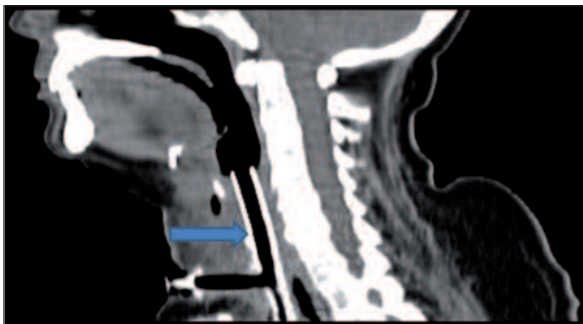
Computed tomography image of the patient one month after the T-tube insertion.
